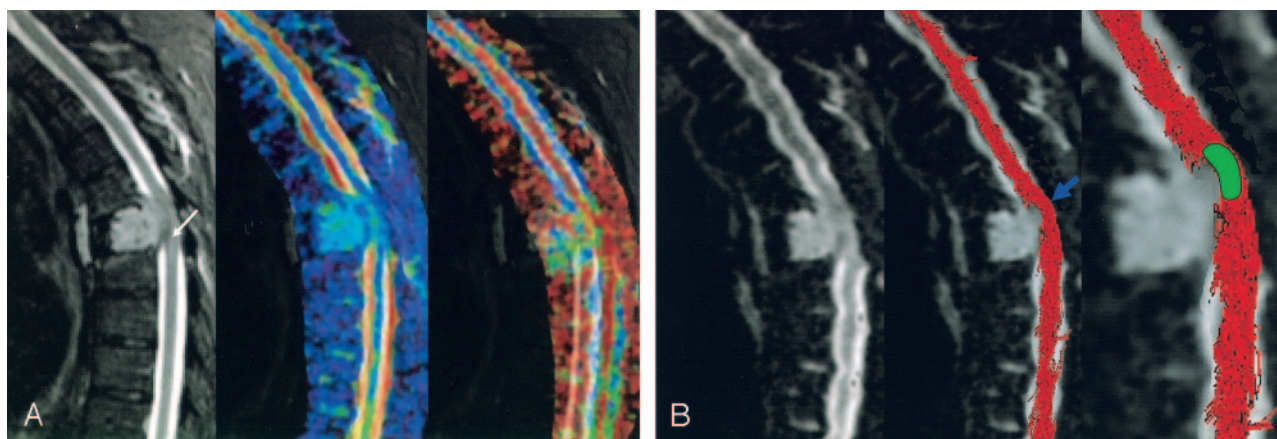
A, MR imaging of a spinal cord compression due to a breast tumor metastasis in patient 1. Images are from C7–T10. Color-coded scale related to parameters values. Higher values are coded in red, medium values in green, and lower values in blue. T2-weighted imaging (first image) shows a high signal intensity (white arrow), ADC (second image) is slightly increased (blue-green areas; $ADC = 1.1 \cdot 10^{-3} \text{ mm}^2/\text{s}$ versus $0.84 \cdot 10^{-3} \text{ mm}^2/\text{s}$ in normal cervicothoracic area) and FA (third image) is decreased (green areas; $FA = 0.61$ vs 0.75 in normal cervicothoracic area) after region of interest measurements. The region of interest in abnormal area was drawn by using the fiber tracking three-dimensional reconstruction.
